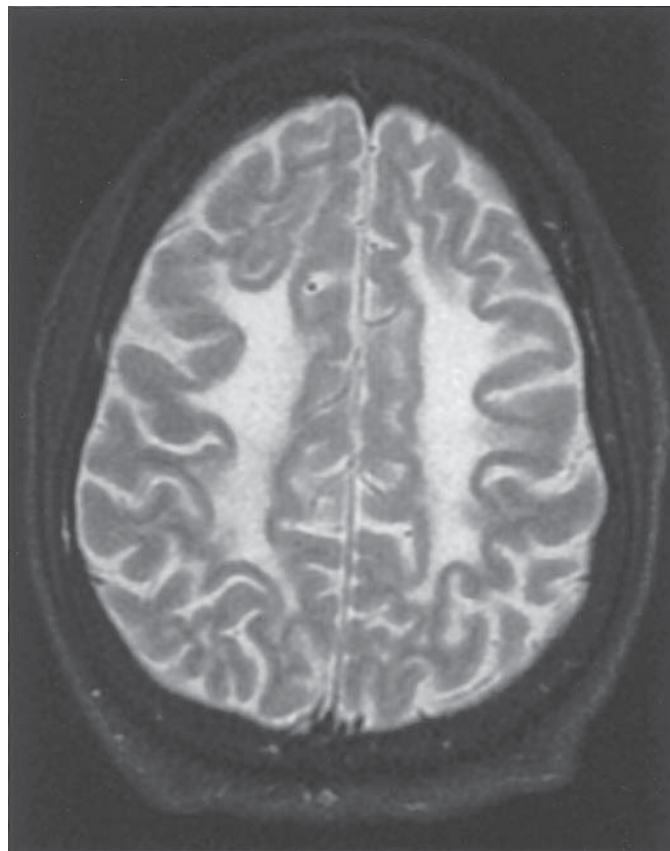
This 22-yr-old patient had a history of acute lymphoblastic leukemia. The patient was treated with radiation (2400 cGy) and chemotherapy, in addition to intrathecal methotrexate, 4 yr previously and now has cognitive impairment. T2-weighted imaging of the brain demonstrates diffuse white matter signal abnormality characteristic of neurotoxicity following radiation and chemotherapy (disseminated necrotizing leukoencephalopathy, DNL).
